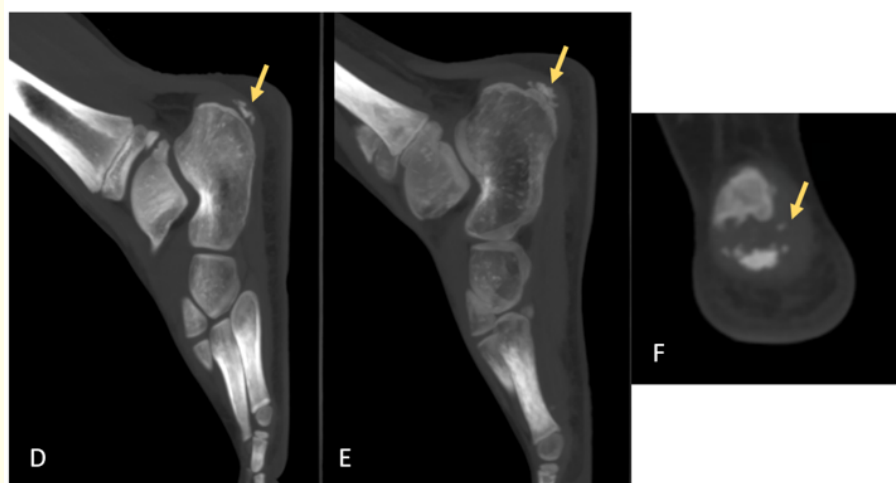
Left calcaneus. Sagittal (D, E) and coronal (F) CT images demonstrate more pronounced irregular fragmentation of the posterior calcaneal apophysis (Yellow arrows), associated with reactive subapophyseal calcaneal sclerosis and inflammatory infiltration with partial effacement of the pre-Achilles (Kager's) fat pad.
